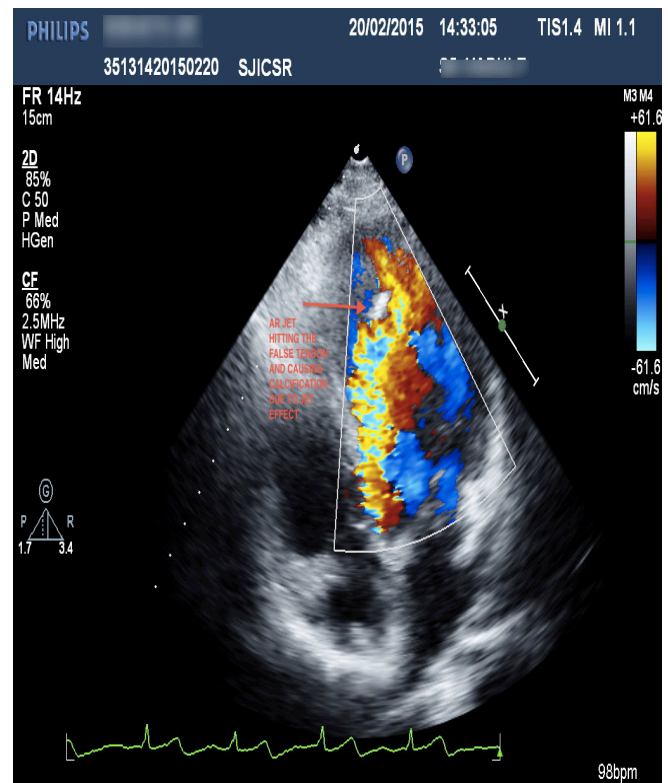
Apical 4chamberview Showing Ar Jet Hitting the False Tendon
